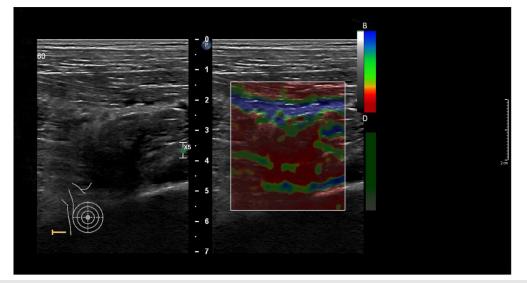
Stream ultrasound image after Physiotherapy treatment.
